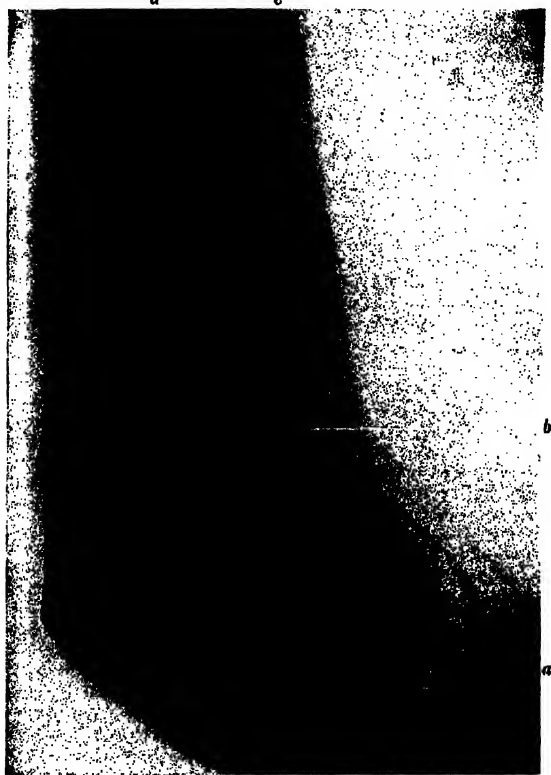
ATHEROMATOUS ARTERIES IN A MAN OF SIXTY-ONE SHOWN BY THE X-RAYS. (Case of Keen, skiagraphed by Manges, Jefferson Hospital.)
